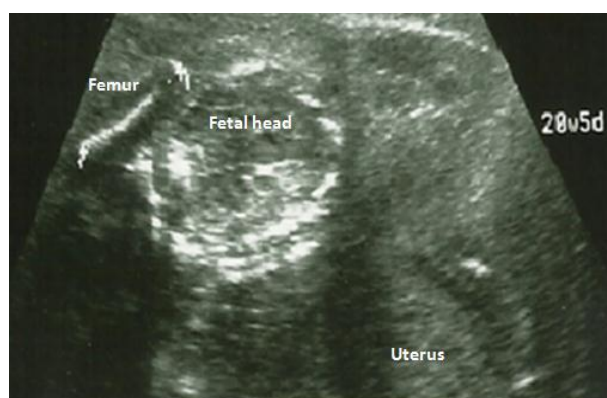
Preoperative ultrasonographic image.
